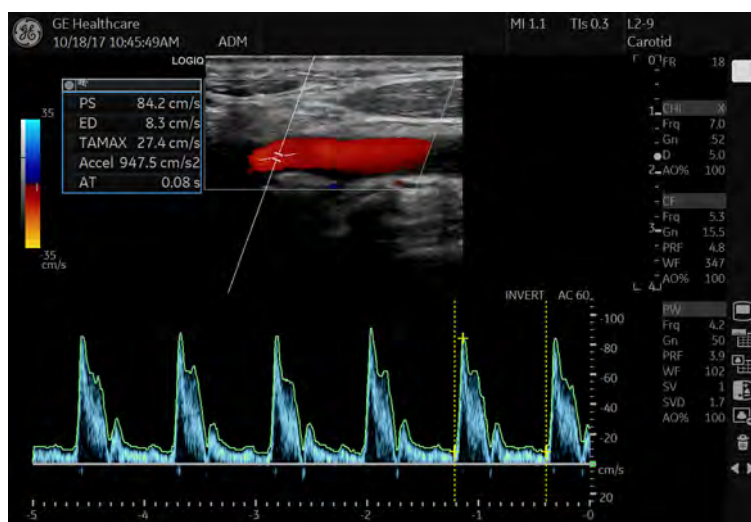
PW Doppler Mode Display
